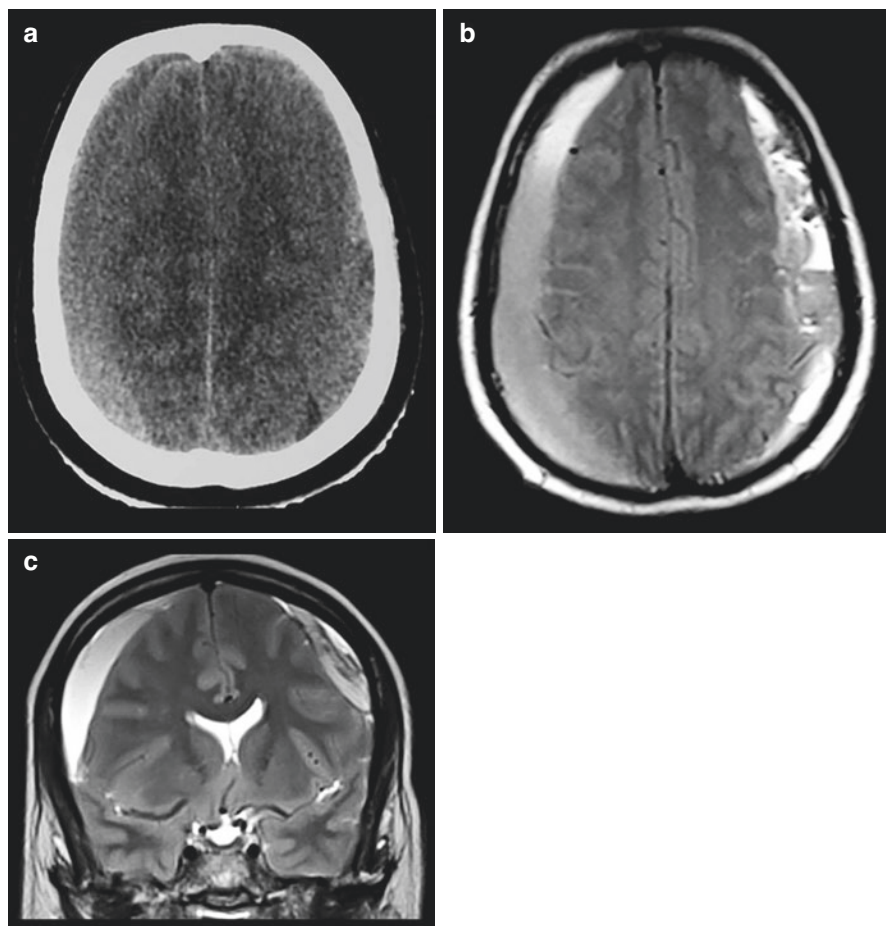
Bilateral intracranial isodense chronic subdural hematoma on CT scan (a). Better distinction of the SDH on MRI: axial (b) and coronal (c) T2-weighted images
